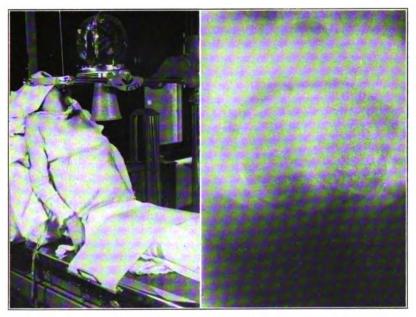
Supero-inferior exposure of the superior strait or inlet of the pelvis in roentgenographic pelvimetry.
